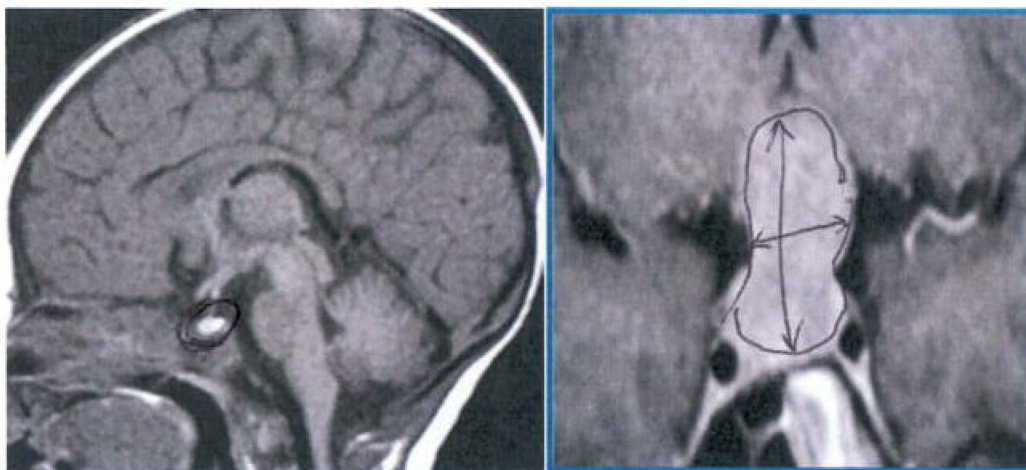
Showing location and appearance of a normal pituitary MRI on the left and a magnified macroadenoma on the right (courtesy of Dr. Evanson, Barts NHS Trust)
